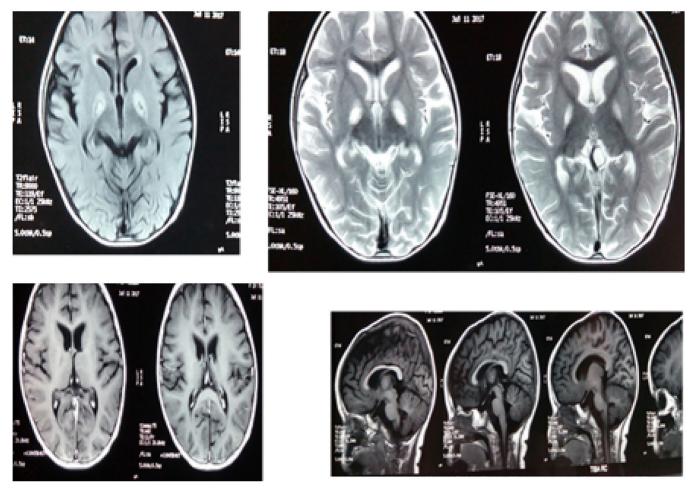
MRI brain of patient 2 showing mild cerebellar atrophic changes, cortical brain atrophy and calcification of the basal ganglia bilaterally.
